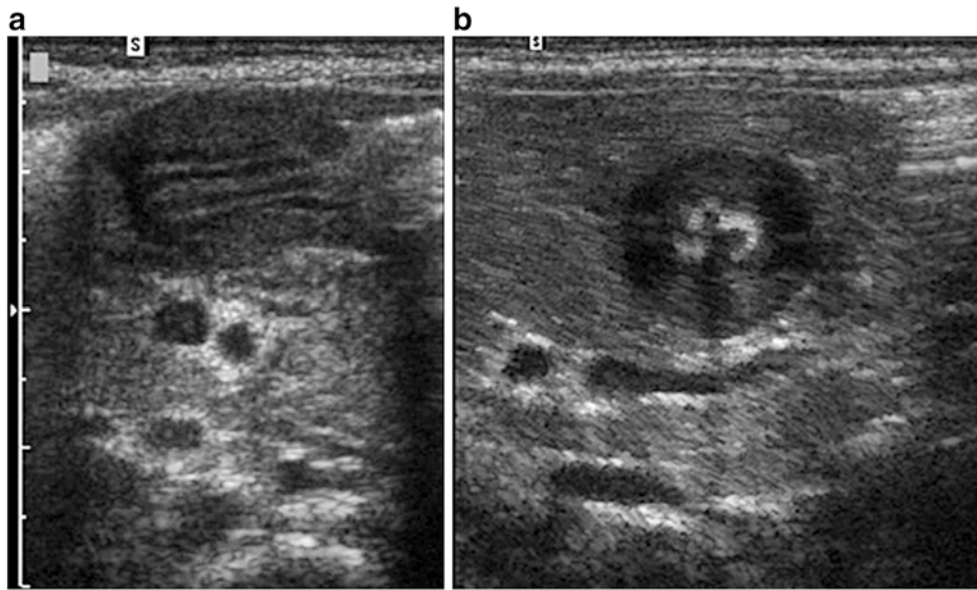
Ultrasonographic images showing pyloric muscle thickness measuring 5 mm. Longitudinal view (a) and transverse view (b)
